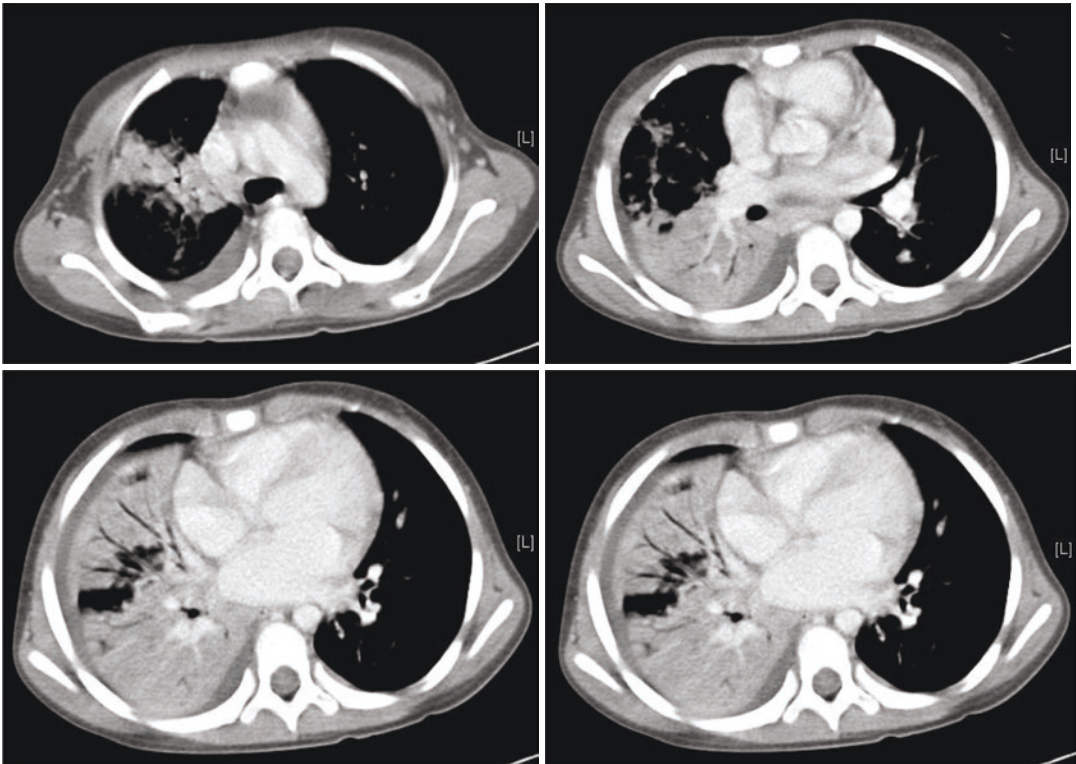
Extensive consolidation with air-bronchogram change of right middle and lower lobe with small amount pleural effusion on computed tomography with contrast enhancement
